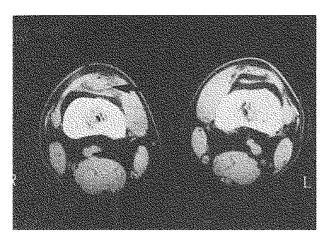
CT-scan: edematic swelling over the quadriceps tendon insertion (arrows).
